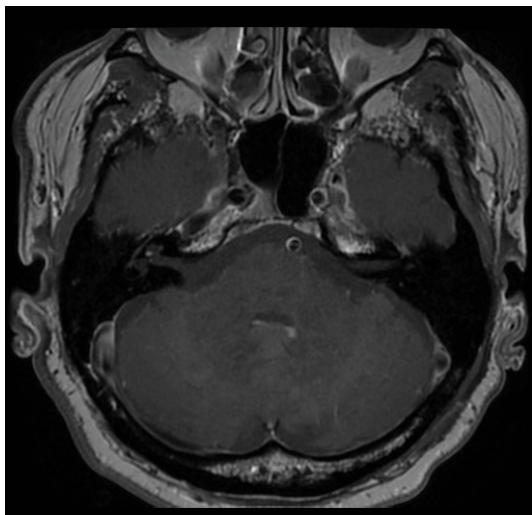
MRI scan of brain.
